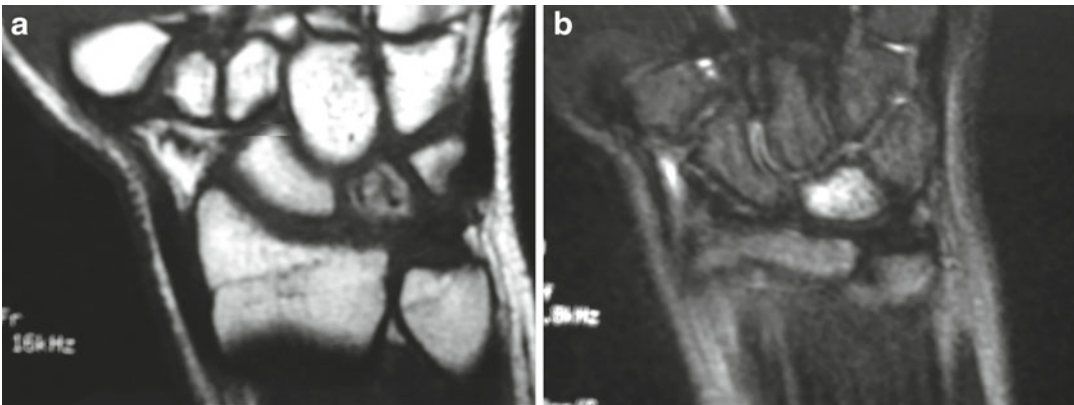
MRI sequences at 3-month follow-up. (a) The T1-weighted sequence shows increased intensity of the lunate compared to the original. (b) T2-weighted image shows a slight decrease in intensity from the original
